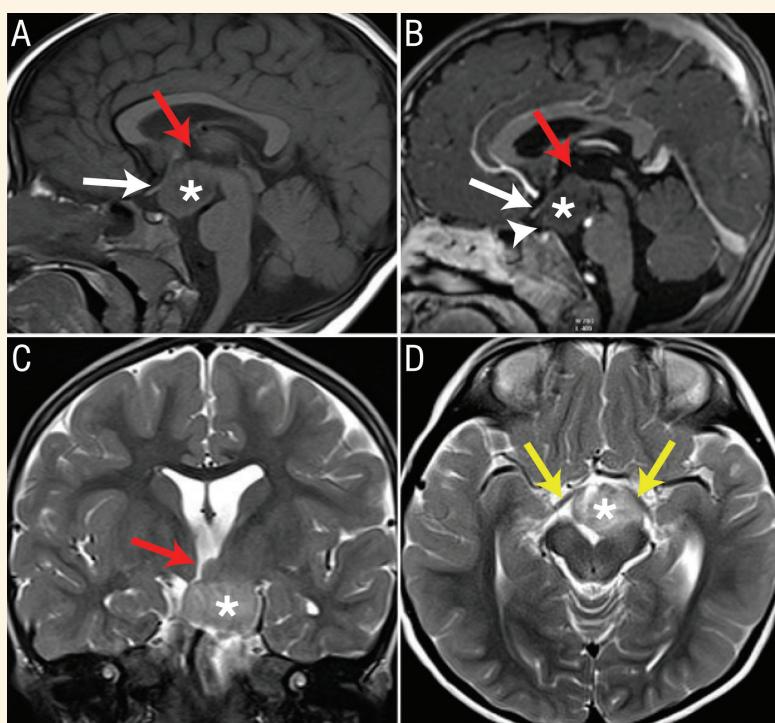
Sagittal T1-weighted magnetic resonance images (MRIs) of the brain of a two-year and seven-month-old boy before (A) and after (B) intravenous gadolinium contrast administration. They show a mass (asterisk) arising from the both above and below the floor of the third ventricle (red arrows). Accordingly, this mass has both vertical and horizontal planes of attachment to the floor of the third ventricle classifying it radiologically as Delalande type III. It occupies most of the suprasellar and interpeduncular cisterns. It compresses the optic chiasm (white arrows) and pituitary stalk (White arrowhead) anteriorly. Coronal (C) and axial (D) T2-weighted MRIs show the mass having a heterogeneous hyperintense signal. It is seen stretching the optic tracts bilaterally (yellow arrows) in (D).
